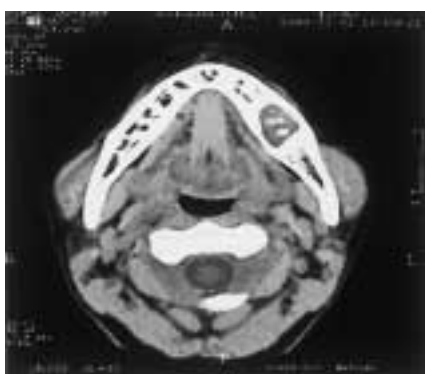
CT image (Axial scan).
